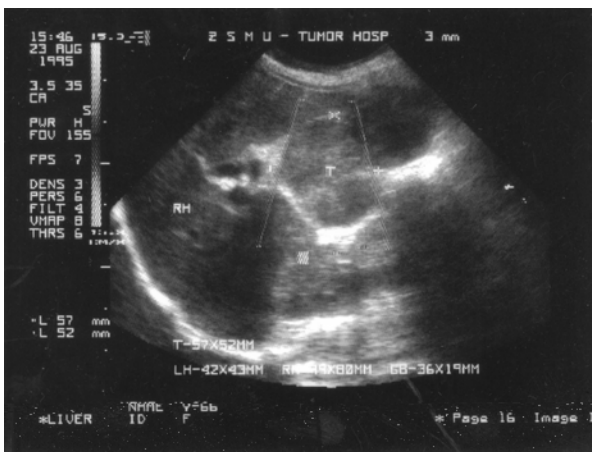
Case 2, male, 72 years old, the mixed pattern of carcinoma of gallbladder by ultrasonography
